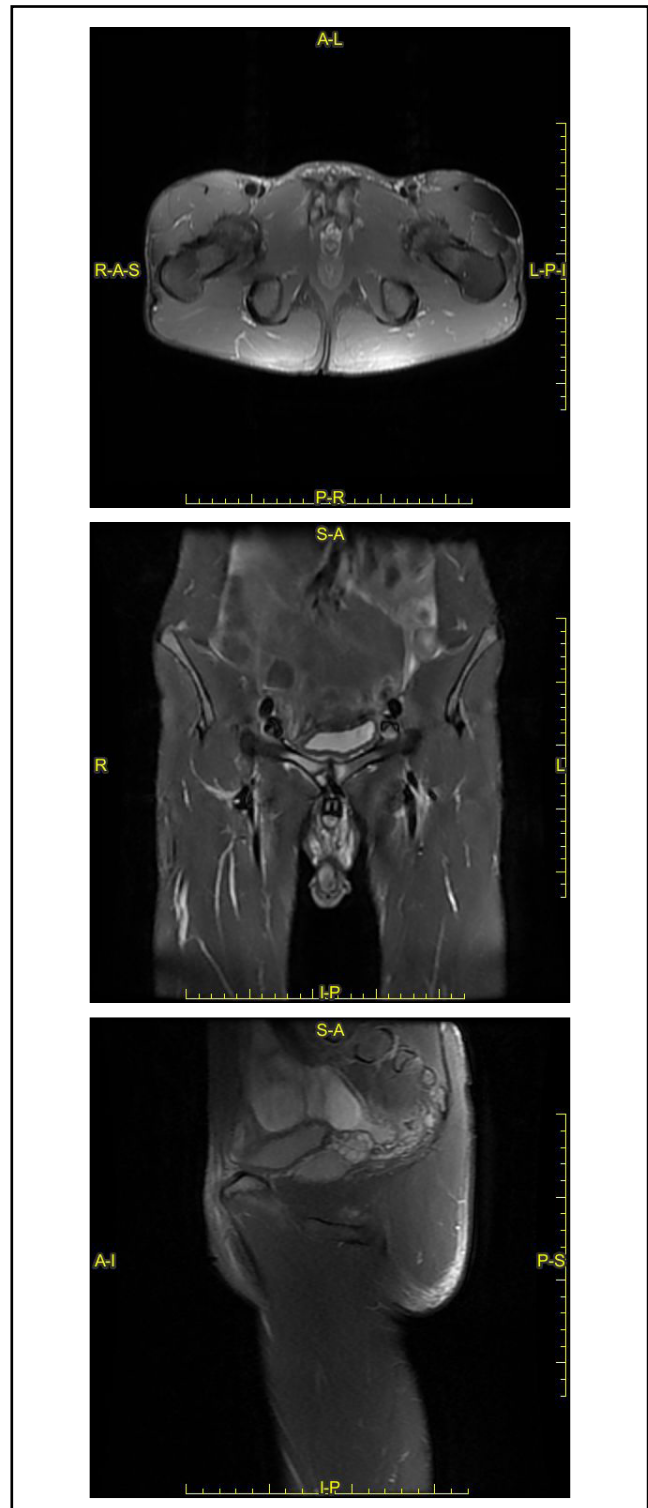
Magnetic resonance imaging of the pelvis, with (A) Axial PD fatsat (proton-density fat saturation), (B) coronal STIR (short TI inversion recovery), and (C) sagittal PD fatsat sequences
